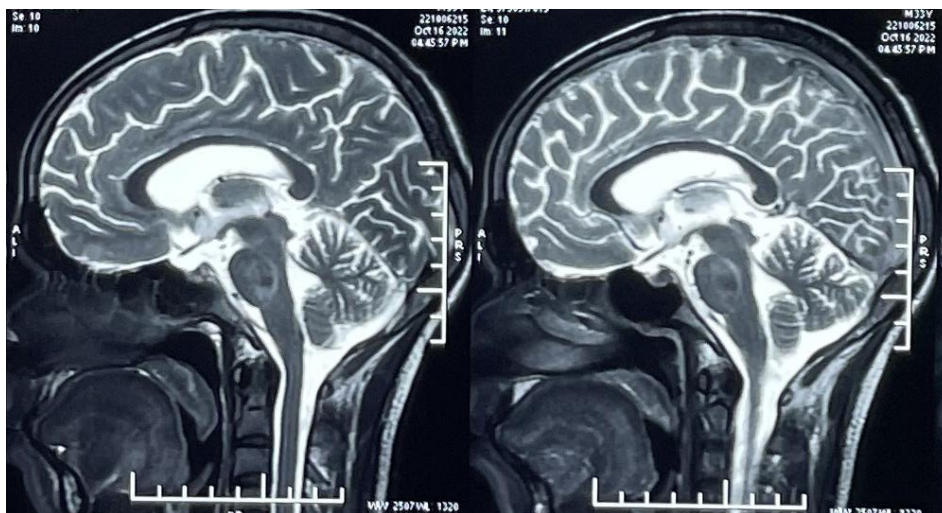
T2-Weighted MRI Brain (coronal section) showing brainstem midline hyperintensity
